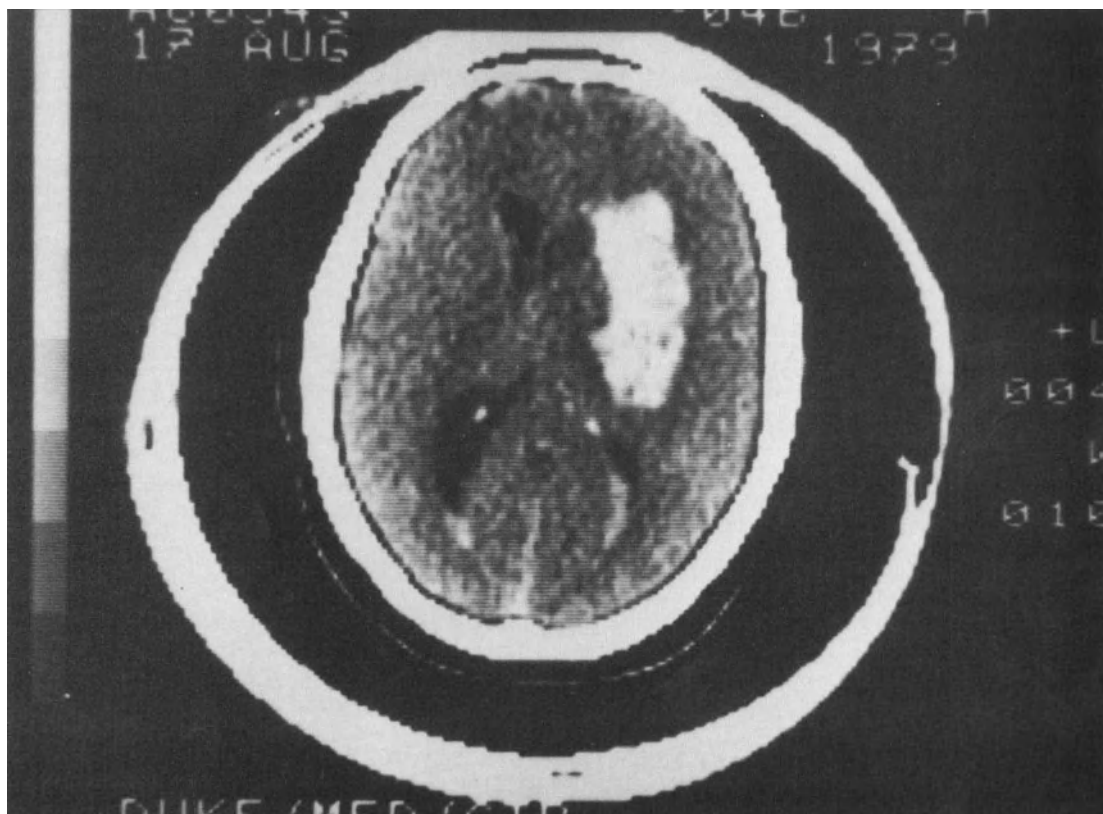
Cranial CT scan demonstrating hemorrhage in the region of the left basal ganglia.
